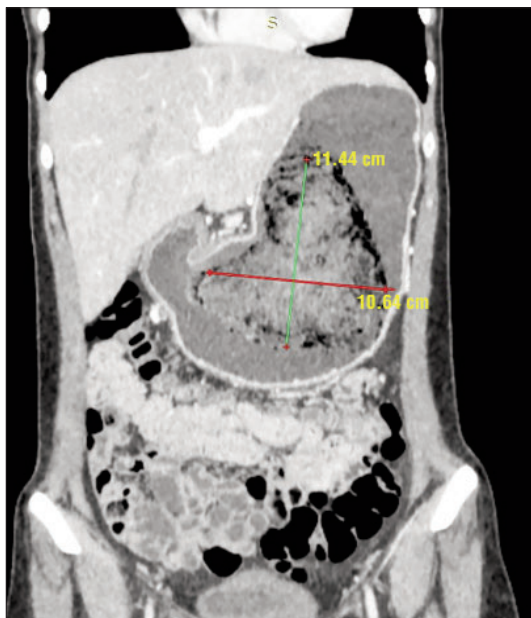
Coronal CT image of gastric trichobezoar
